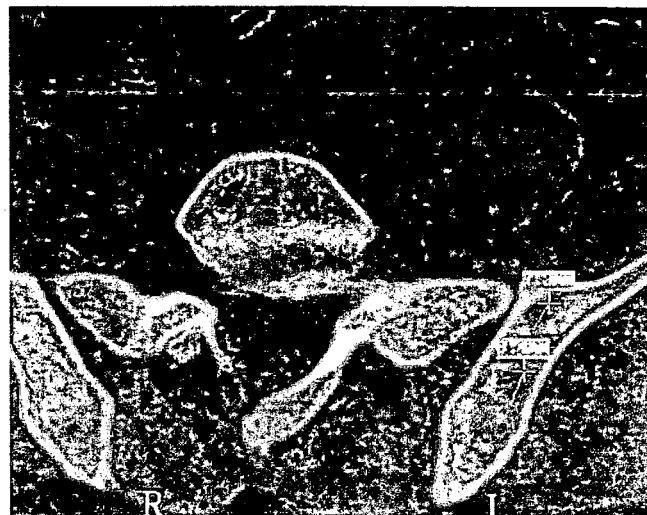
Computed tomography scan of the left iliac bone showing multiple punched-out defects about one millimeter in diameter.
